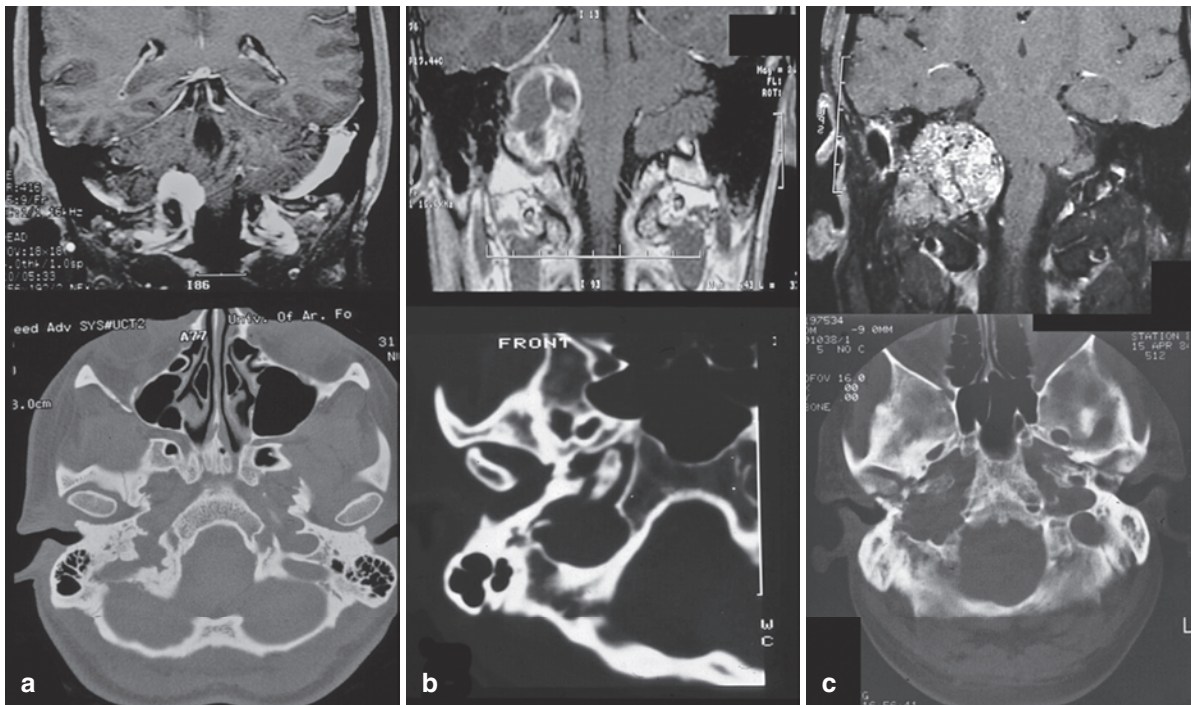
(a–c) Comparison imaging of different tumors within the jugular fossa. (a) MRI and CT of jugular foramen meningioma demonstrating features of homogeneous contrast enhancement, presence of a dural tail, and hyperostosis of the jugular tubercle. (b) MRI and CT of jugular foramen schwannoma demonstrating presence of large cyst, dumbbell shape, and sclerosis of bone. (c) Glomus jugulare tumor demonstrating heterogeneous contrast enhancement, serpiginous flow voids, and bony destruction on CT
